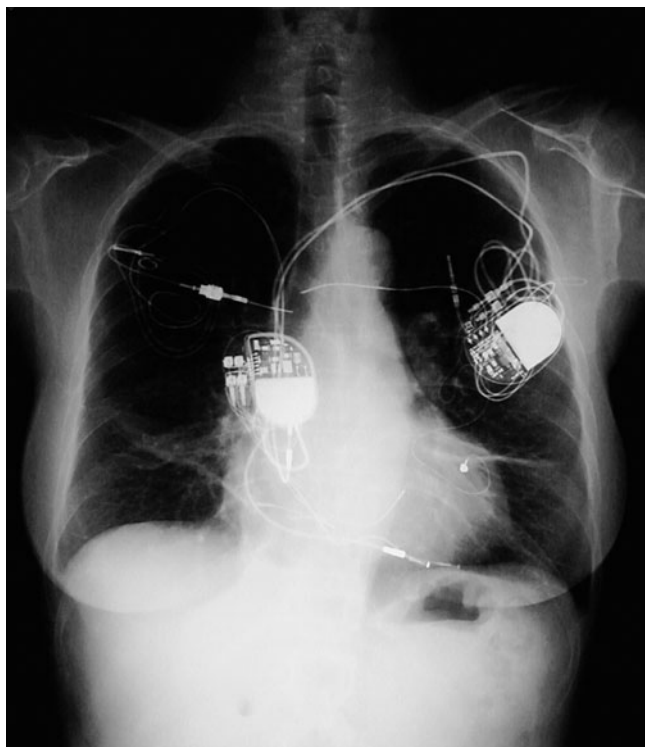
X-ray of a patient with very poor escape rhythm, bilateral venous obstruction, and severe exit block. A new pacing system was inserted through the right atrial appendage via right parasternal mediastinotomy. Her old pacemaker was programmed to back-up mode and scheduled for removal at a later date.
